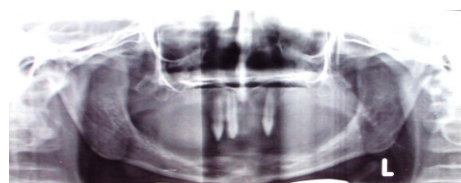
Panoramic radiograph showing presence of UR1, UR2 and UL3
